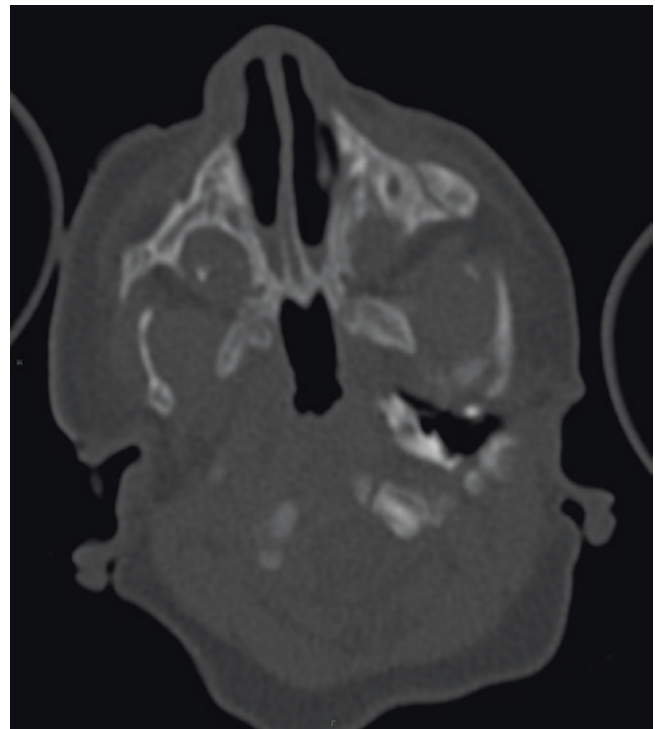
Bilateral bony choanal atresia. Axial CT image shows obliteration of the posterior choana bilaterally due to a bony bar. The vomer is thickened and there is medial deviation of the posterior maxilla bilaterally. Bilateral fluid collections are present in the choanae
